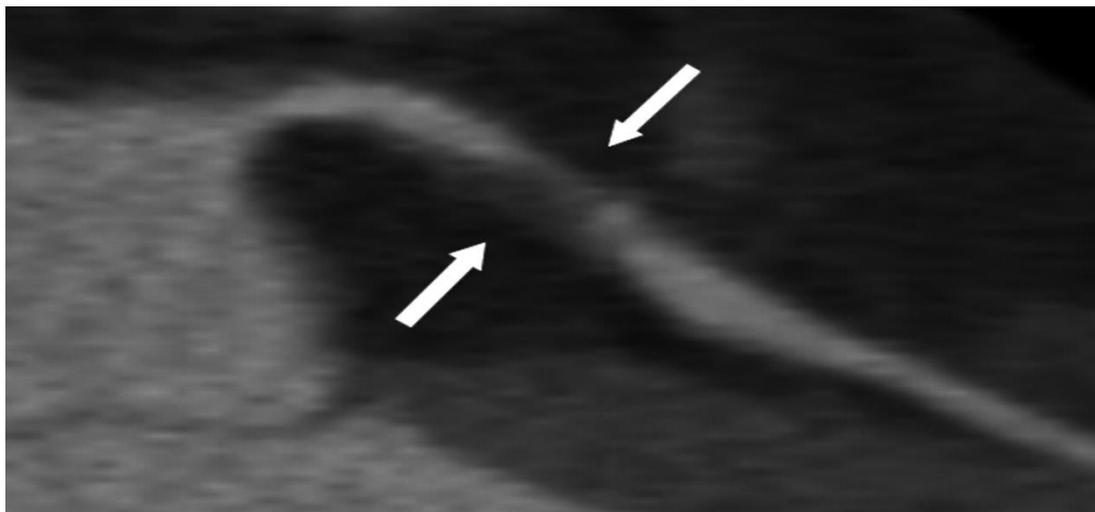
52-year-old man with increased fatigue on long-distance runs. Coronary CT angiography image shows large soft plaque (between arrows) that is causing severe stenosis in the left main coronary artery. (25)
